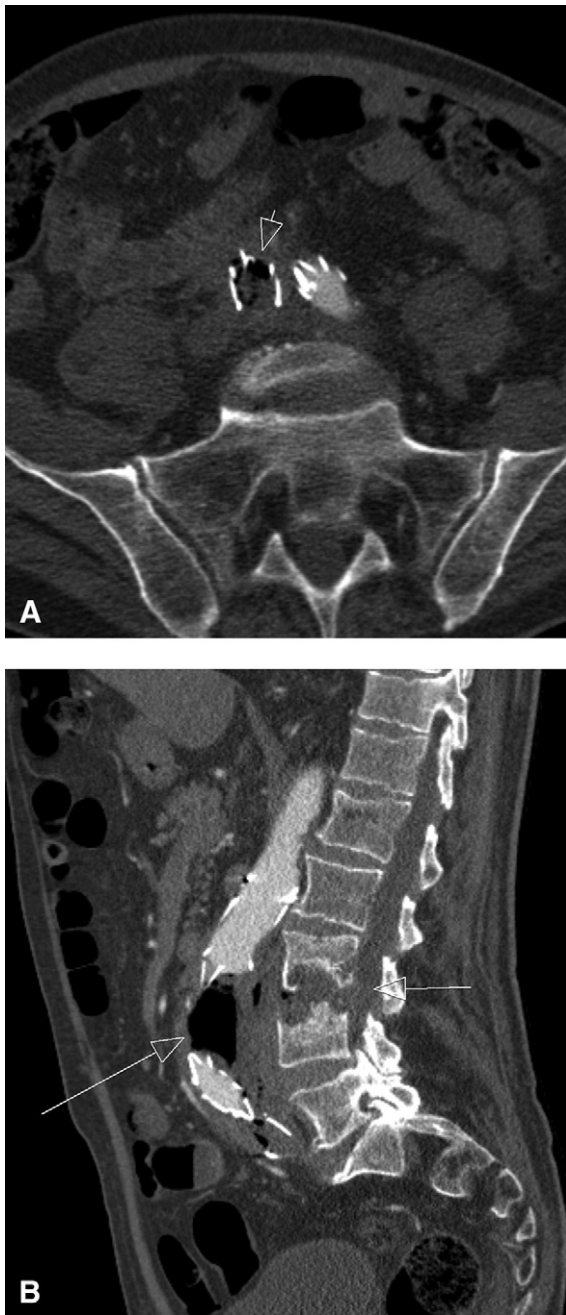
Abdominal computed tomography (CT)-scan 6 months after endovascular repair of an infrarenal aneurysm. A, Transversal view at the level L5-S1 showing an ileal loop in close proximity to the occluded right leg of the endograft, which is filled with air. B, Sagittal view showing an abscess with air/fluid level in the excluded aortic aneurysm, air in and around the occluded right leg of the endograft in continuity with destructive spondylodiscitis L3-4.
